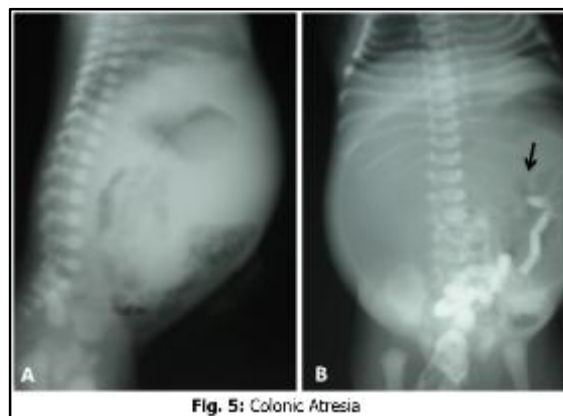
(A). Plain X-ray Abdomen lateral view in a case of colonic atresia at the level of splenic flexure shows grossly dilated proximal large bowel loops with absence of rectal air bubble. (B). Water soluble contrast enema shows a small and narrow distal colon with abrupt cut off at the splenic flexure (arrow).
